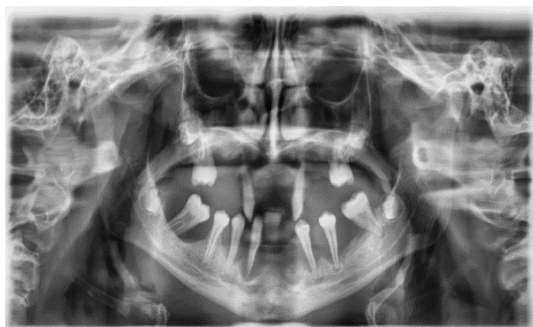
Old panoramic x-ray extraction showing the absence of several teeth and the presence of severe bone loss on all remaining teeth with radiolucent periapical images
